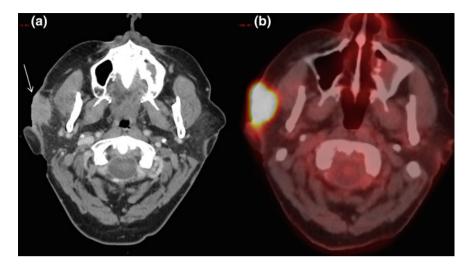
Metastatic SCC to the parotid. a Contrast-enhanced CT. b PET-CT. Infiltrative dermal cancer invading into the superficial right parotid gland (*arrow*). Avid FDG avidity
